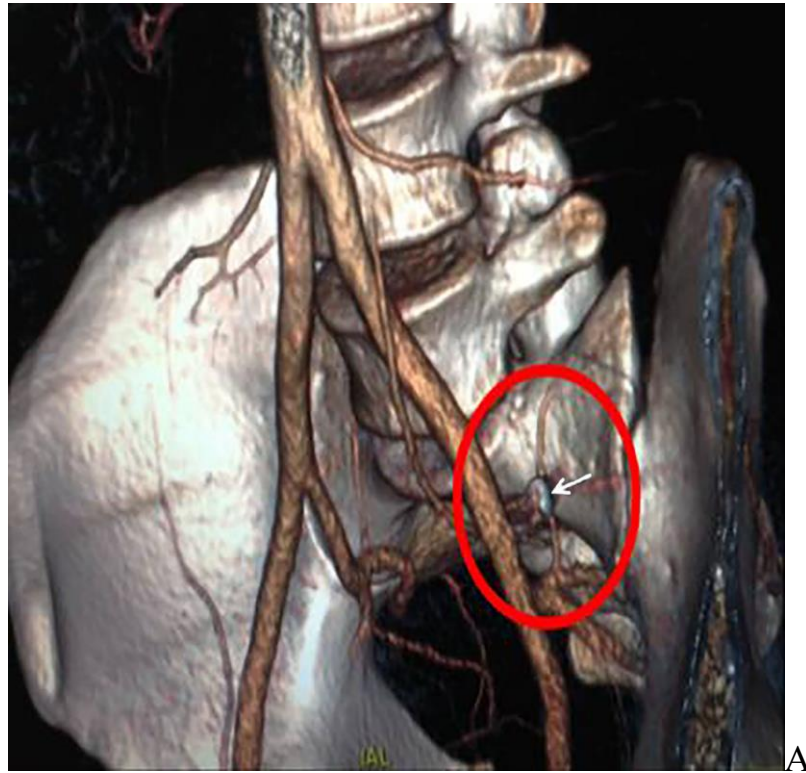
Penetrating gunshot wound to the abdomen, CT angiography (A) and X-ray angiography (B) demonstrate a metallic fragment (arrow) at the bifurcation of the left common iliac vein.
